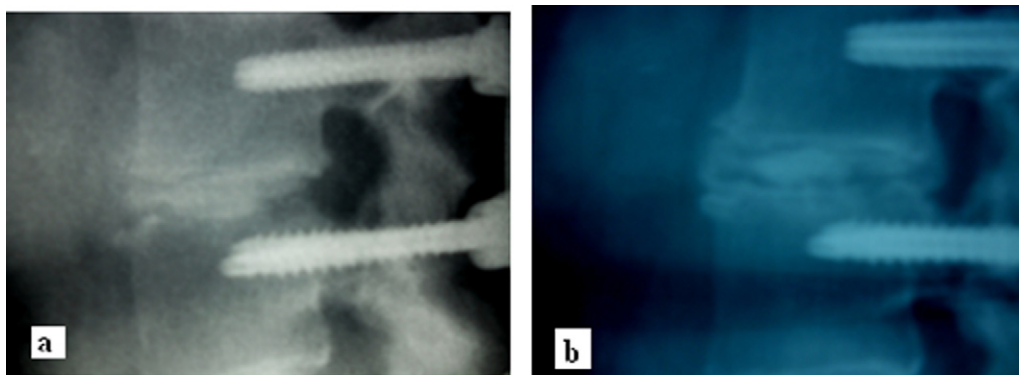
Radiographic results following lumbar fusion.
